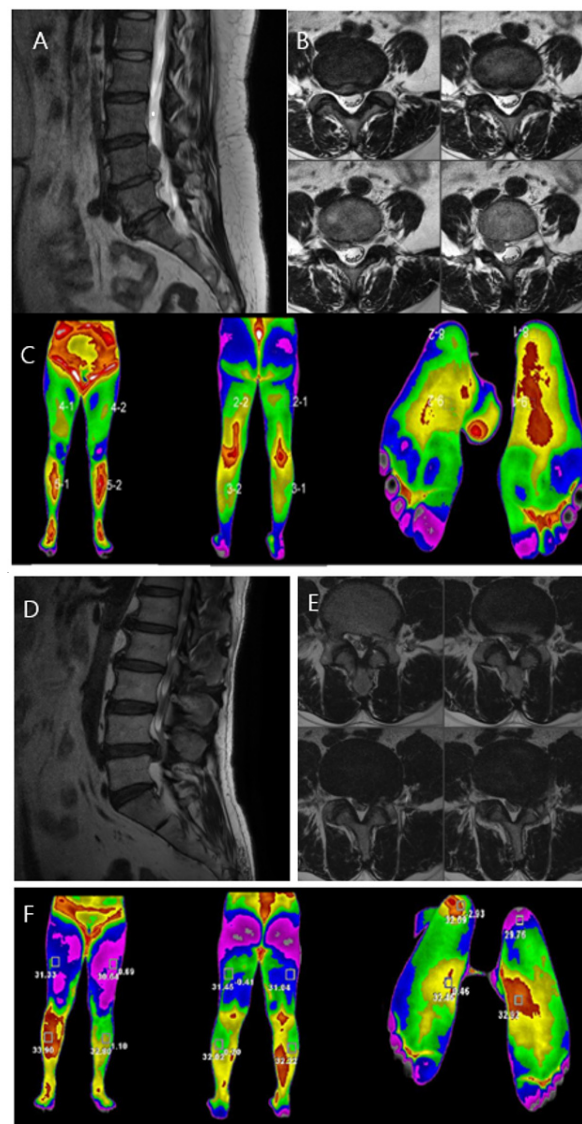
Case comparison of the differences in the lower leg temperature distribution according to pain severity in patients with lumbosacral radiculopathy. (A,B): MRI showing HLD L4/5, Rt. with upward migration. Sagittal and axial views. (C): DITI image showing high temperature at L4/5 dermatome, right side. (D,E): MRI showing HLD L4/5, Lt. Sagittal and axial views. (F): DITI image showing high temperature at L4/5 dermatome, right side with high temperature difference between both sides.
